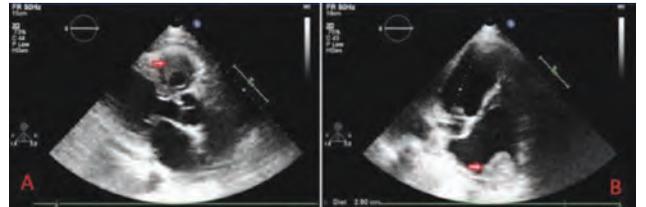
Two-dimensional echocardiogram shows endocardial thickening and fibrothrombotic obliteration of the right ventricle (A) and a large immobile thrombus in the right atrium (B).
